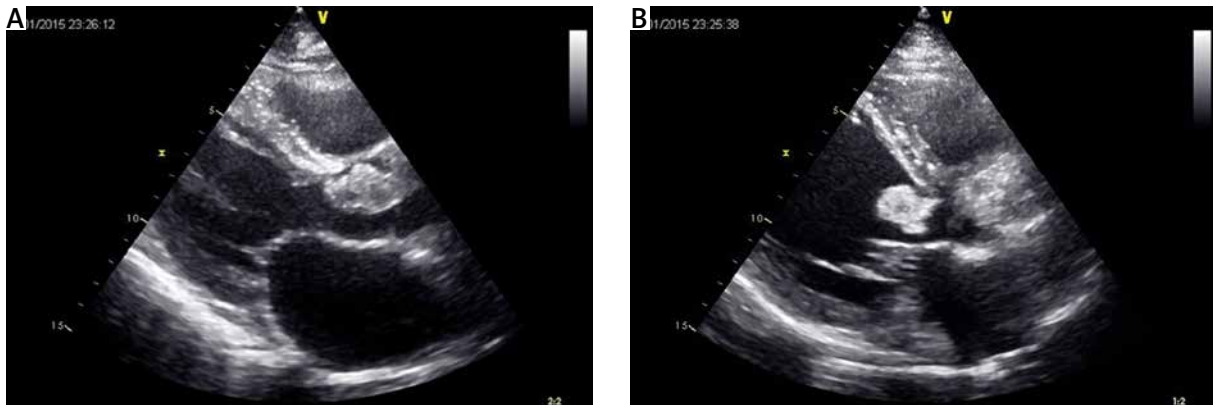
A, B – Echocardiographic assessment of a mass
